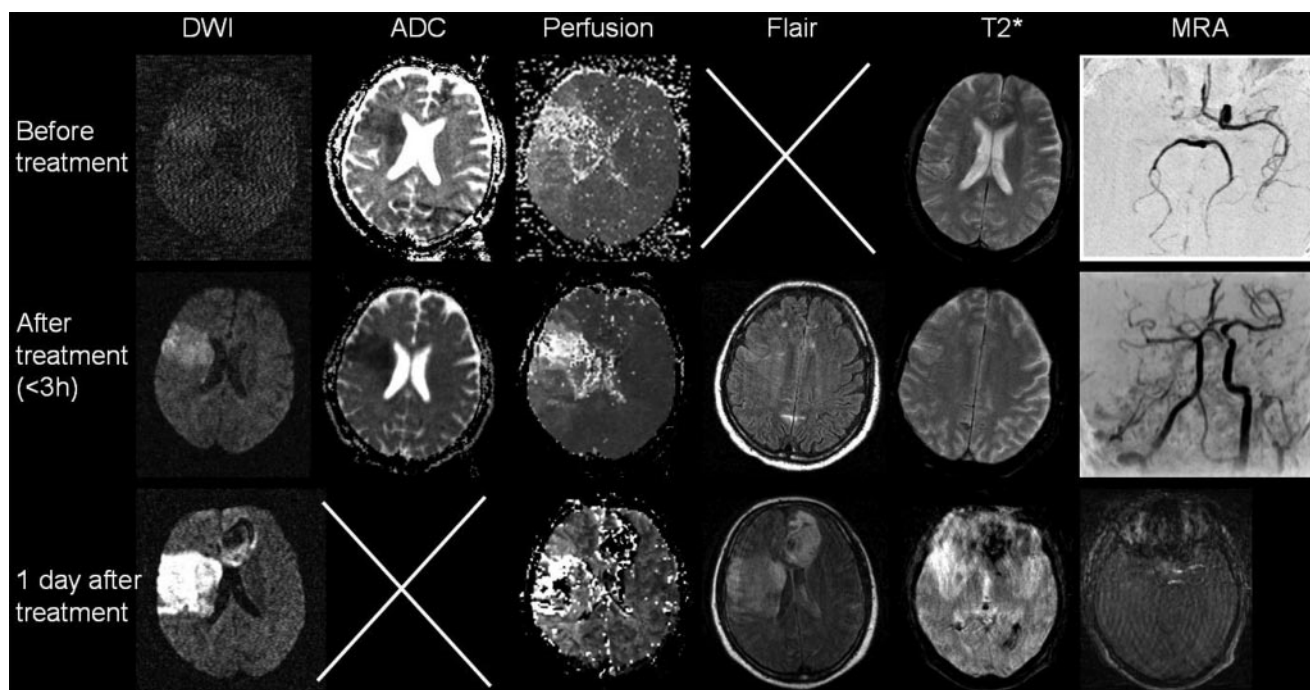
A 68-year-old patient with an acute left-side hemiparesis (NIH 13). Treatment (tPA plus ultrasound) started 160 minutes after symptom onset. Pretreatment MRI (upper row) showed left hemispheric hypoperfusion extending the DWI deficit. T2* imaging revealed no signs of bleeding. MRA showed occlusion of the ICA and T-junction. Posttreatment MRI (middle row) displayed some SAH but no PH in T2* and FLAIR measures. MRA showed no recanalization. Posttreatment NIH was 14. Follow-up MRI 18 hours after symptom onset (lower row) was conducted earlier because of vomiting and somnolence. DWI and FLAIR imaging showed middle cerebral artery infarction on the right side. T2* and FLAIR measures also showed extended SAH particularly in the frontal area on the right side and a significant PH in the left frontal region distant from any ischemia. NIH was 18. The patient deteriorated the next day, showing loss of consciousness and progressing signs of brain pressure despite maximal treatment, and died on day 3.
